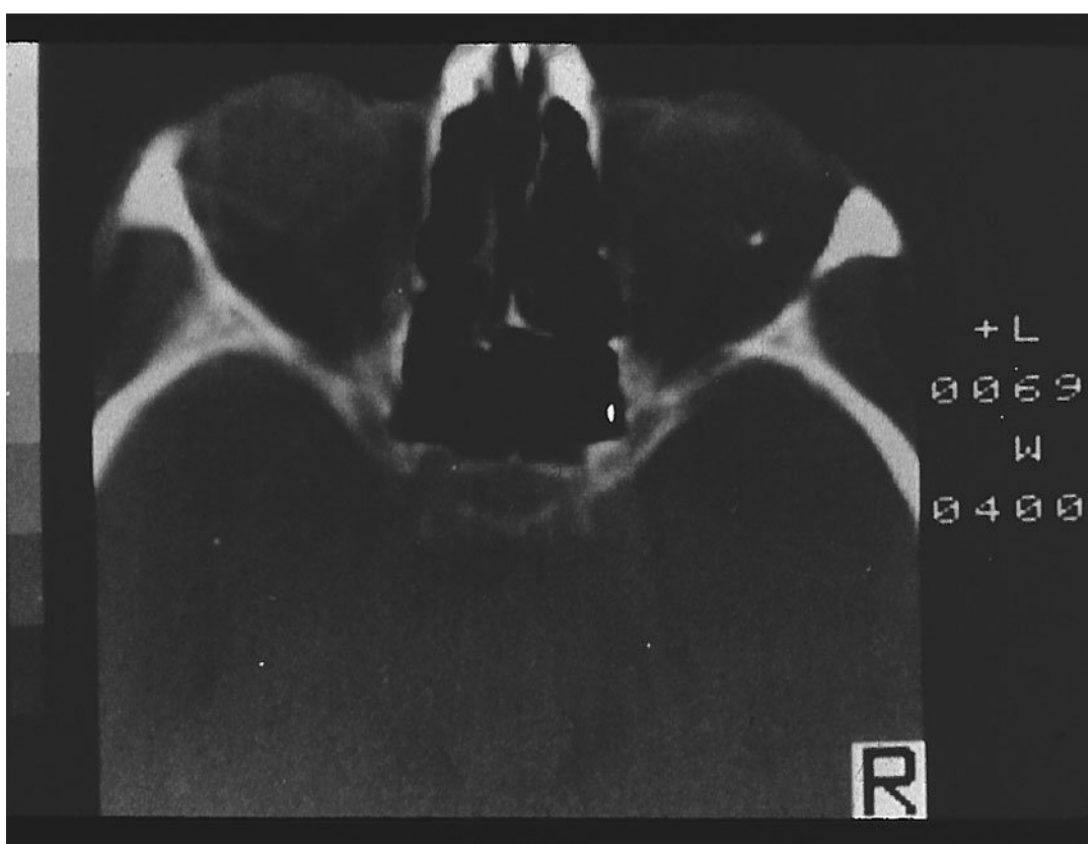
CT image of a patient with IOFB. The radiopacity at the posterior and temporal eye wall of the patient's right eye depicts the IOFB.
